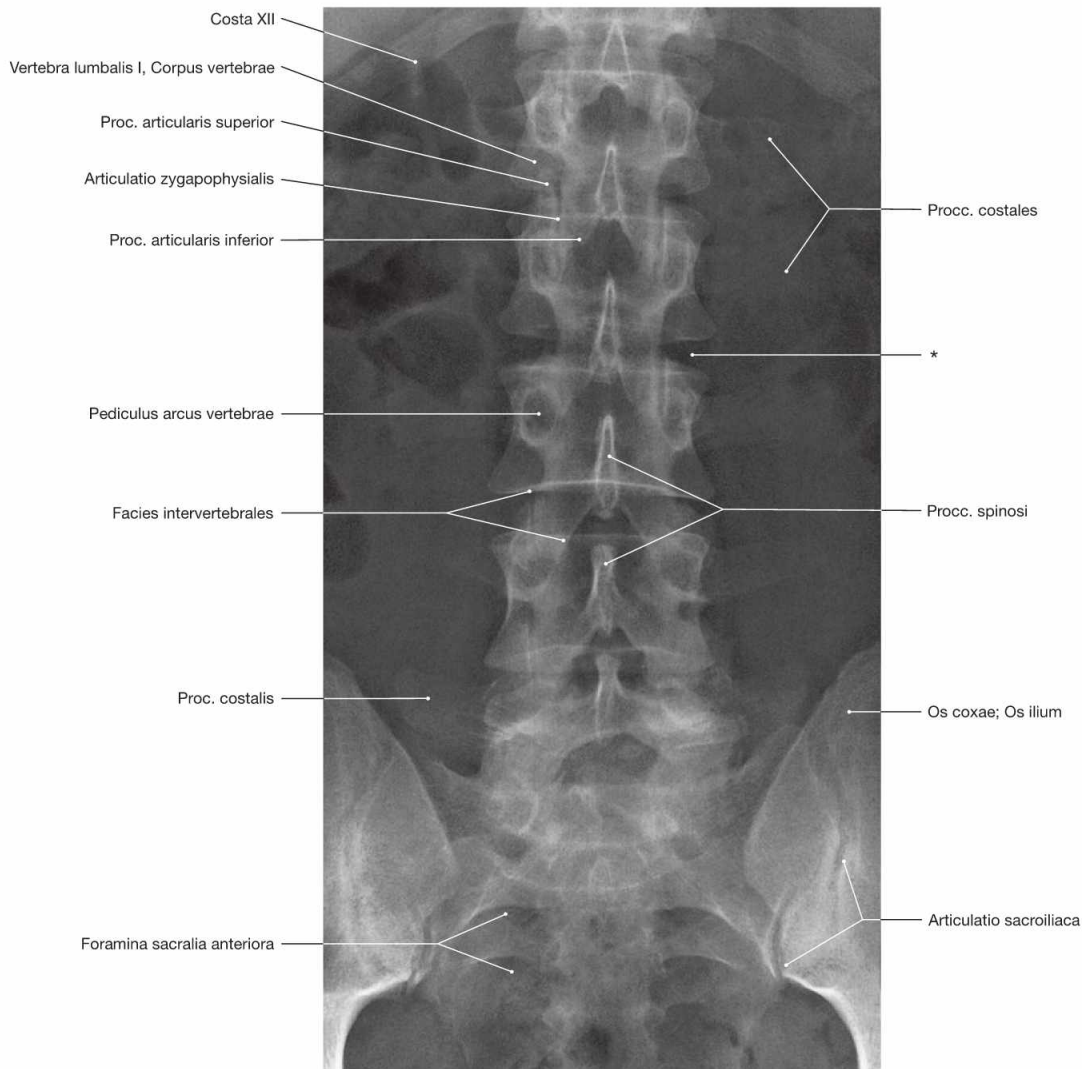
Lumbar vertebrae, Vertebrae lumbales, and sacrum, Os sacrum; AP-radiograph of the lumbar part of the vertebral column and sacrum; upright position; central beam is directed onto the 2nd lumbar vertebra.
